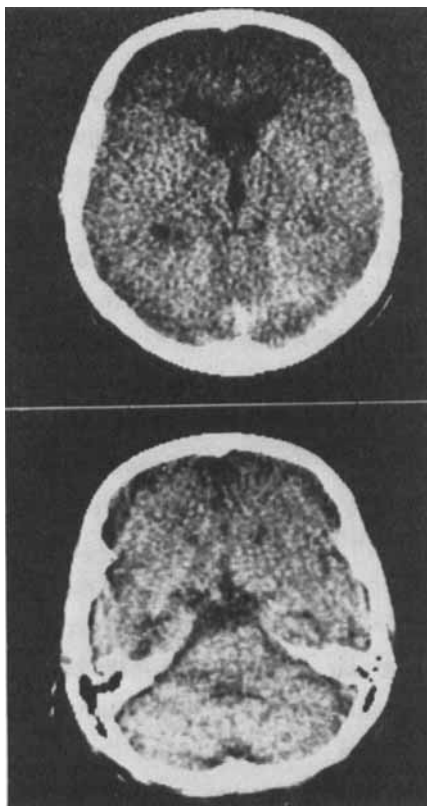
CT performed 18 months after the ingestion of SFMA. Enlargement of the basal cisterns, lateral ventricles and third ventricle, which show a different shape from Figure 2, due to a different angulation of the patient's head.
